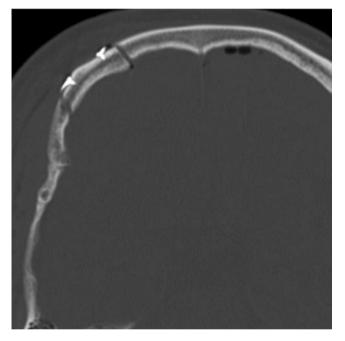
Postoperative CT scan showing proper position of the re-fixated bone flap (Copyright retained by Dr. Henry W. S. Schroeder. Used with permission)
